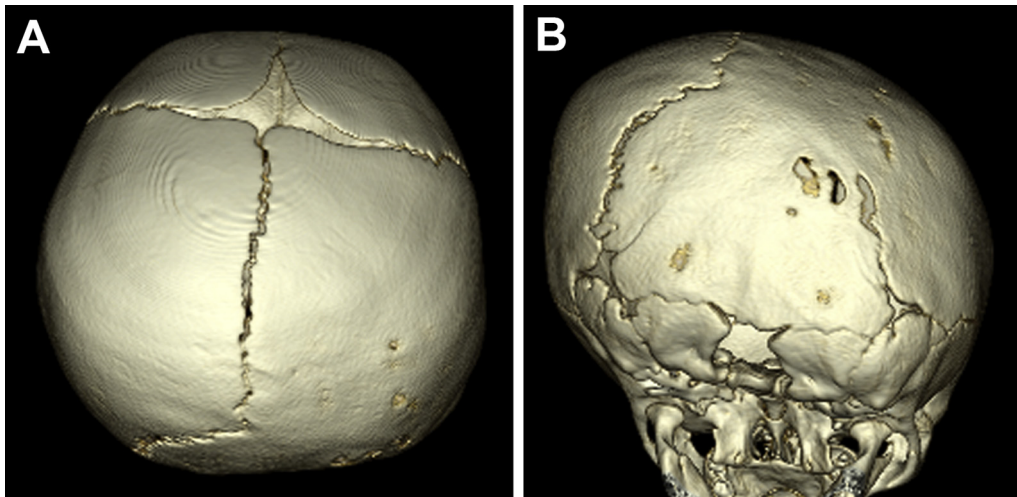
Lambdoid craniosynostosis. Top (A) and back (B) views of a three-dimensional computed tomography scan showing closure of the right lambdoid suture. The skull has a trapezoidal shape with right posterior flattening and posterior displacement of the right forehead. If it were visible, the ear ipsilateral to the posterior flattening would be posteriorly displaced. Also seen is inferior elongation of the ipsilateral mastoid that would also displace the ipsilateral ear inferiorly. (The color version of this figure is available in the online edition.)
